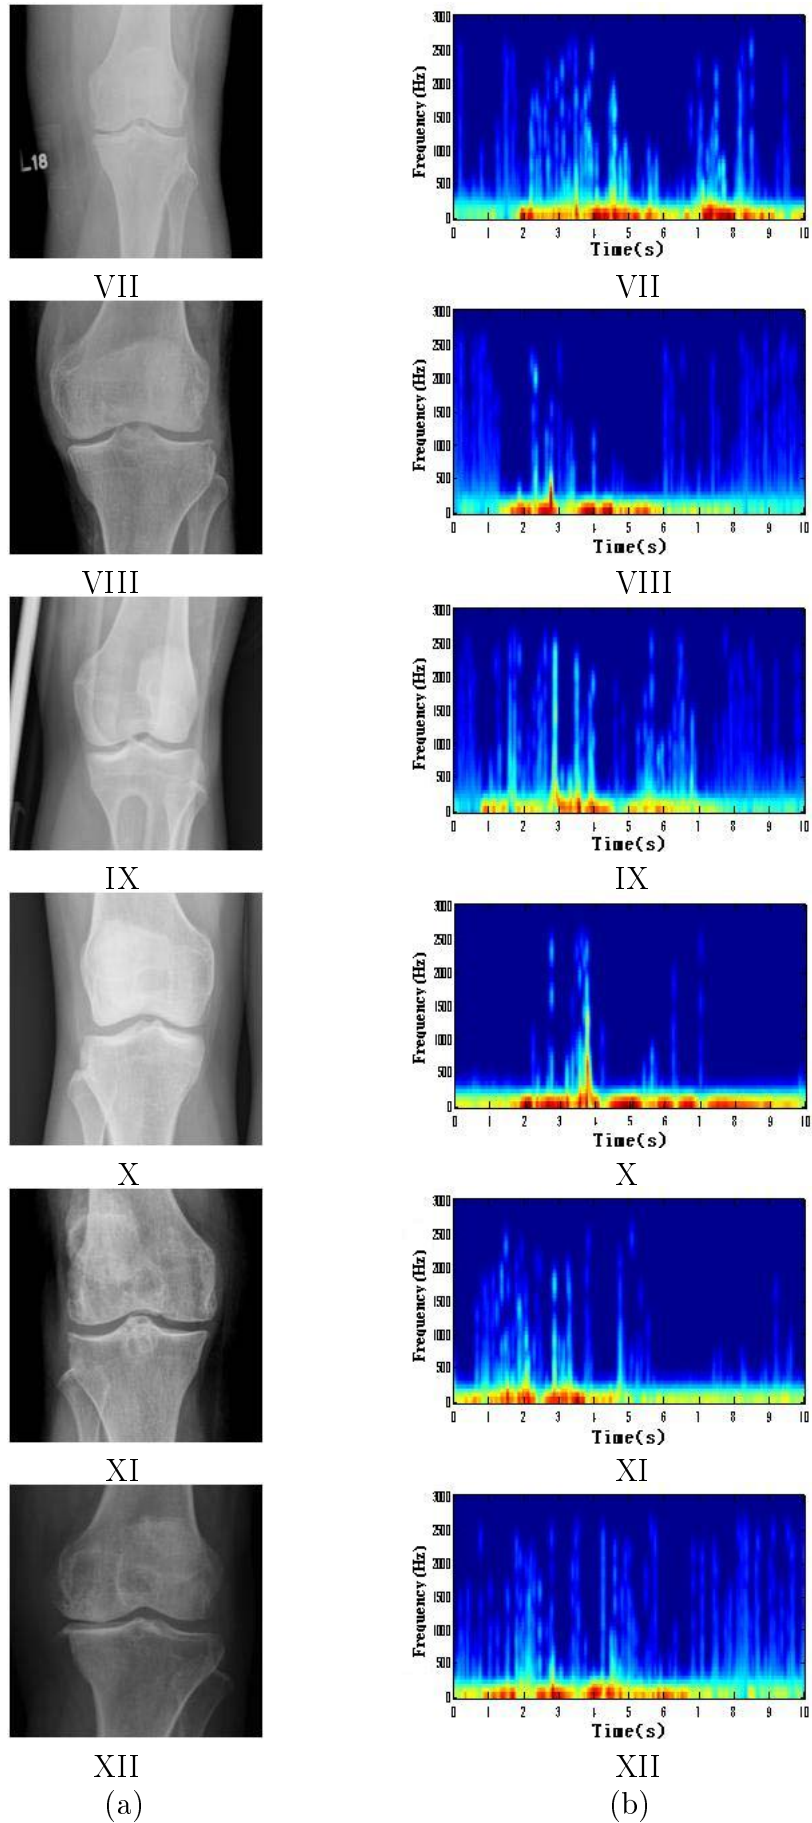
(a) X-ray image of abnormal knee, (b) time-frequency analysis of VAG signals
